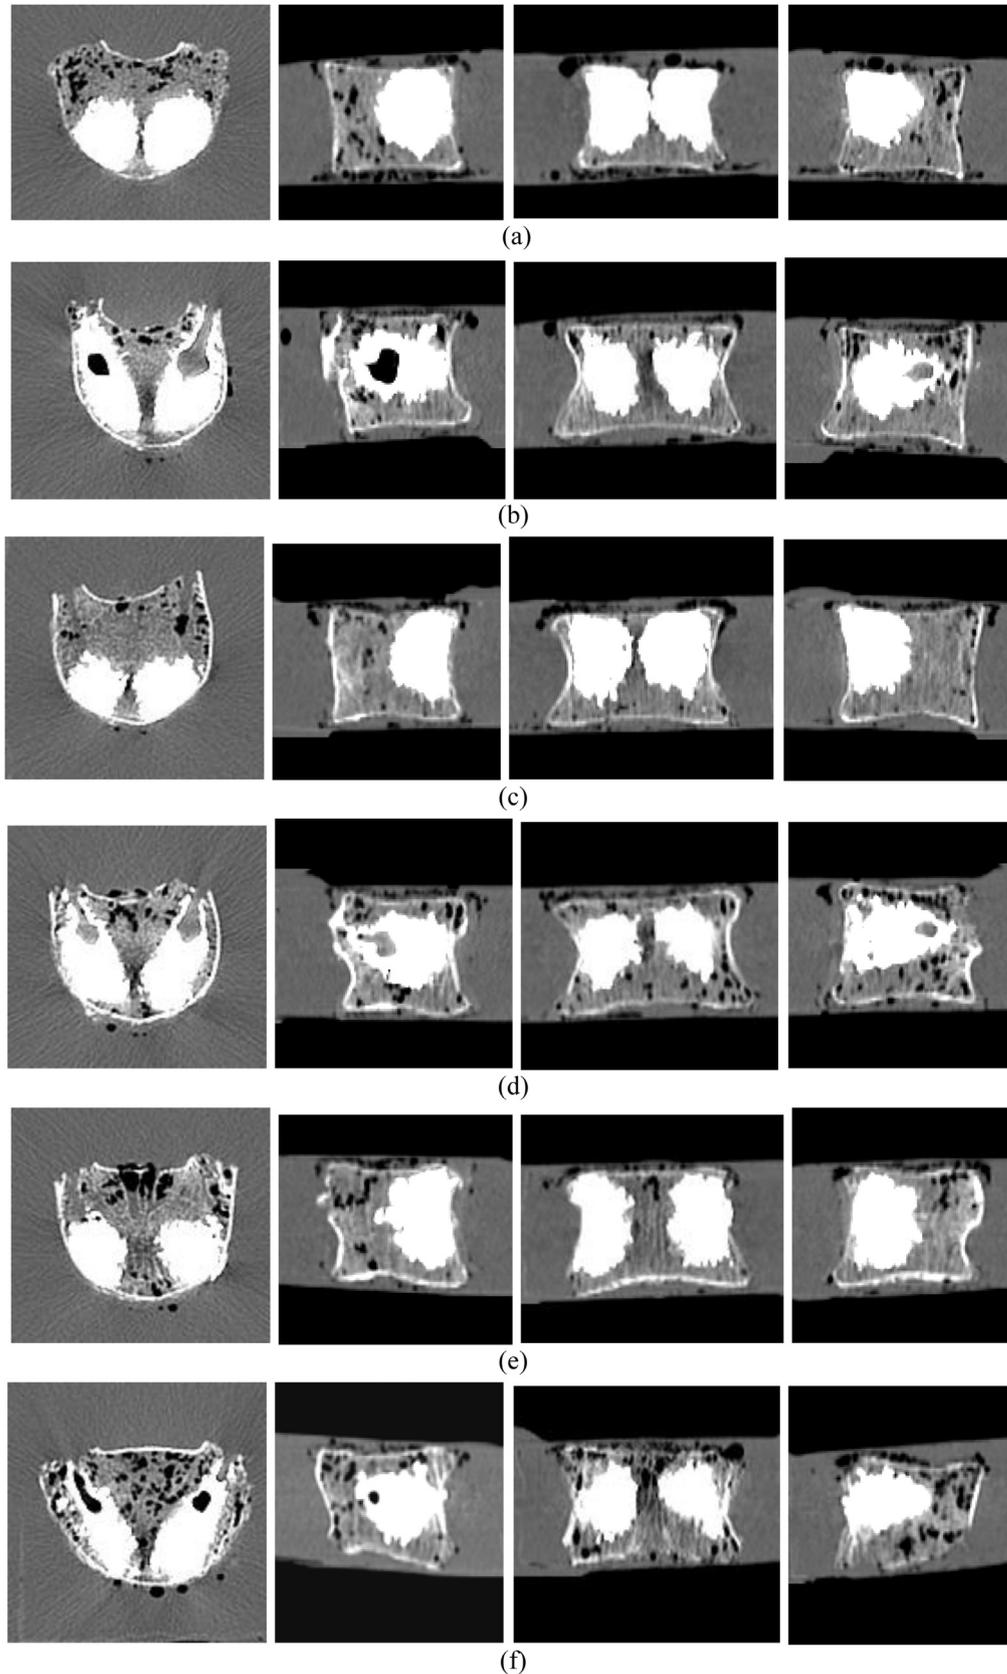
Series of transverse, left sagittal, coronal and right sagittal (from left to right) post-op CT slices of the lumbar spinal vertebrae of a 58 years old man. (a) T12, VP; (b) L1, KP; (c) L2, VP; (d) L3, KP; (e) L4, VP; (f) L5, KP. T refers to thoracic, L to lumbar, VP to vertebroplasty and KP to kyphoplasty.
